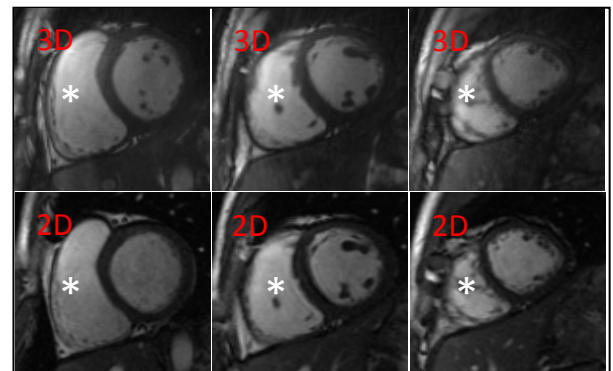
Representative end-diastolic (right) and end-systolic (left) images using 3D free breathing (top) and breath-hold 2D (bottom) cine-MRI. RV noted by asterisk.
